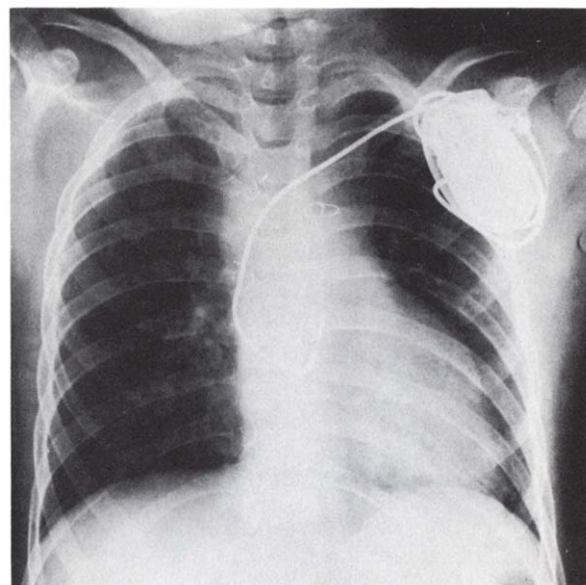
Chest radiograph showing an atrial demand pacemaker with a polyurethane tined "J" lead placed by a left subclavian vein puncture. This 5 year old girl had Mustard's operation for transposition of the great arteries.
